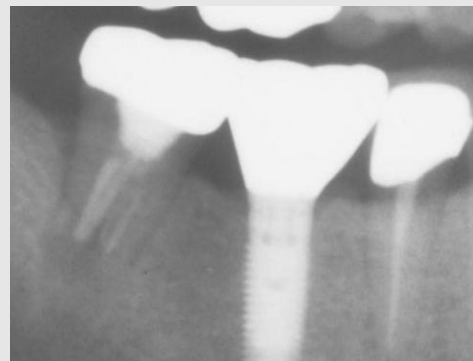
Failure case: post-op periapical view.
